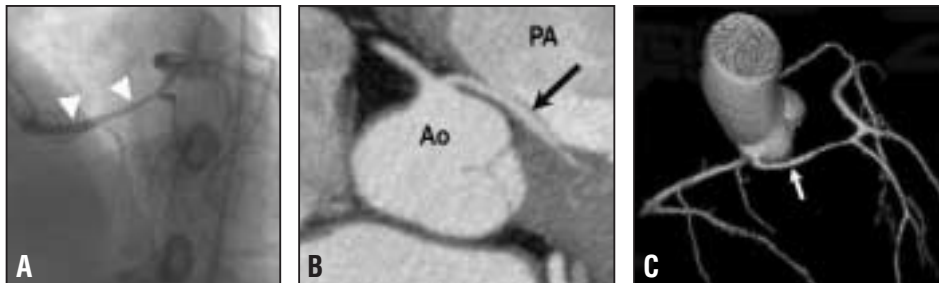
Anomalous left main coronary artery in a 47-year-old. A: Conventional angiography depicted a very long left main (LM) coronary artery, but its course was unclear. B: Coronary CTA depicts a common origin of the left and right coronary arteries from the right coronary sinus. The anomalous LM courses between the aorta (Ao) and pulmonary artery (PA). C: 3D view of the CTA depicts the elongated LM.
